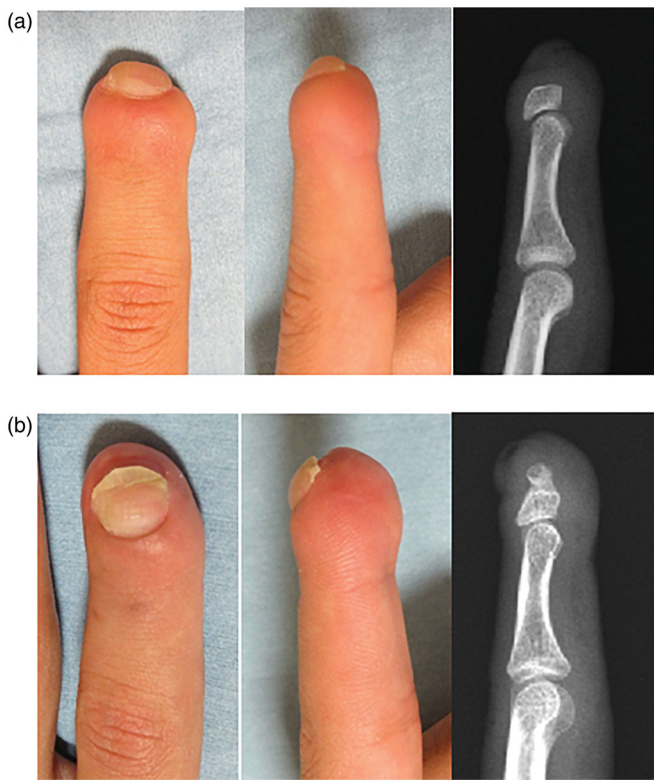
17-year-old man, left index finger. (a) Preoperatively, a-1: frontal view, a-2: lateral views, a-3 lateral view in X-ray. (b) Nine months after reconstruction with a reverse digital arterial finger flap and bone grafting from the second toe. b-1: frontal view, b-2 lateral view, b-3 lateral view in X-ray.
